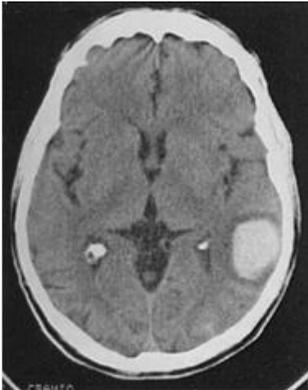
Evolution of intracerebral hemorrhage over time on brain computed tomography (A: acute phase; B: subacute phase; C: outcome phase) and magnetic resonance imaging (T2* sequences; D: acute phase; E: subacute phase; F: outcome phase). Images from Radiopedia: .
